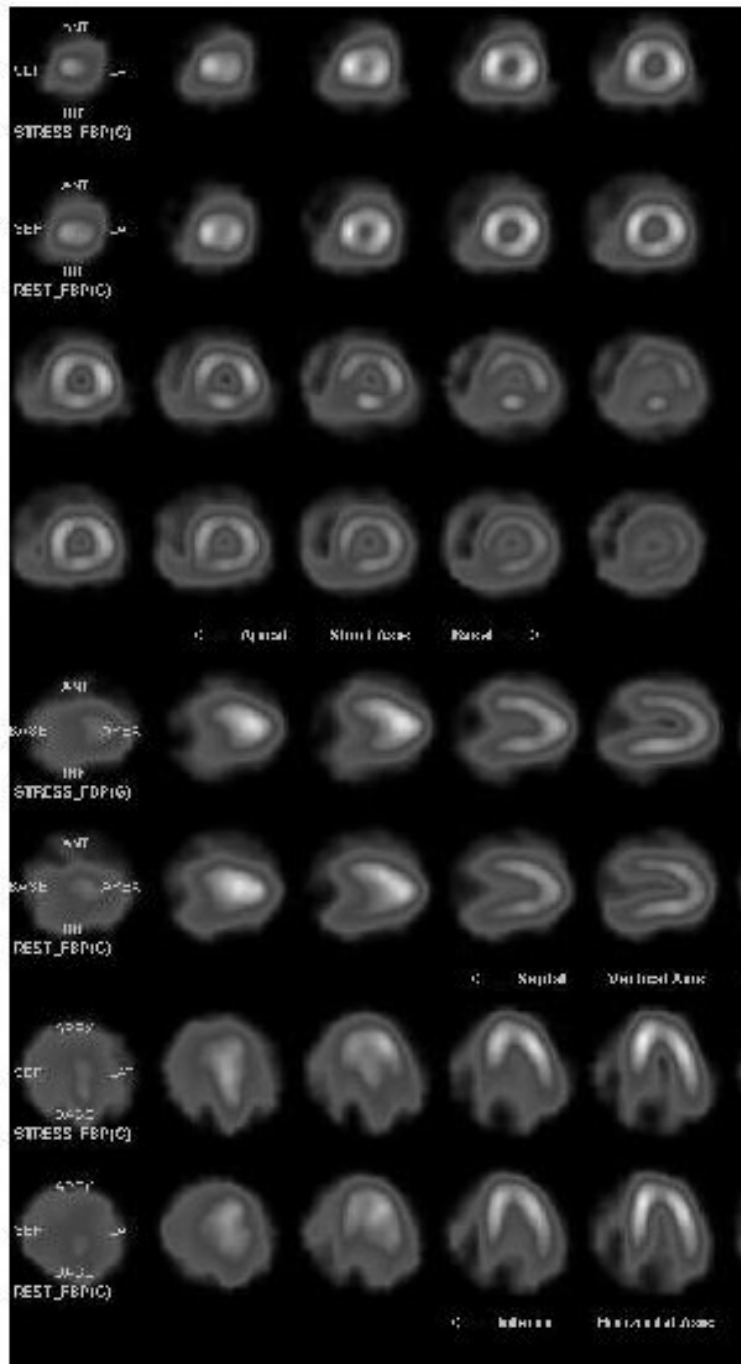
Reconstructed SPECT slices
